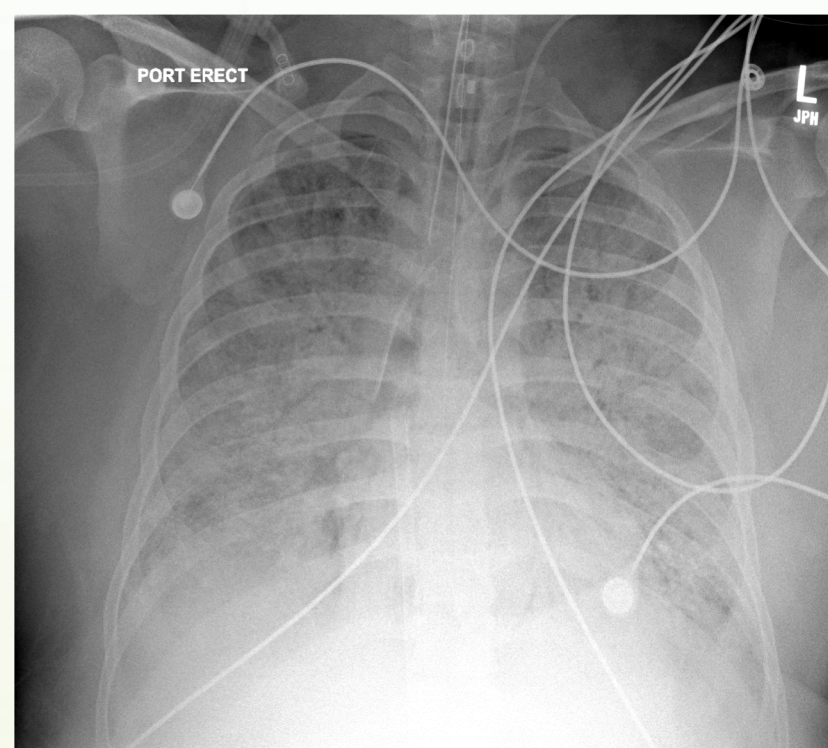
COVID-19 Lung X-Ray in Patient with End-Stage COVID-19
